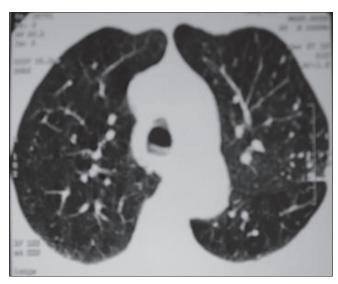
High-resolution computed tomography chest of case of mycosis fungoides with nodules in the bilateral lung fields involving upper lobe, more on the left side.
